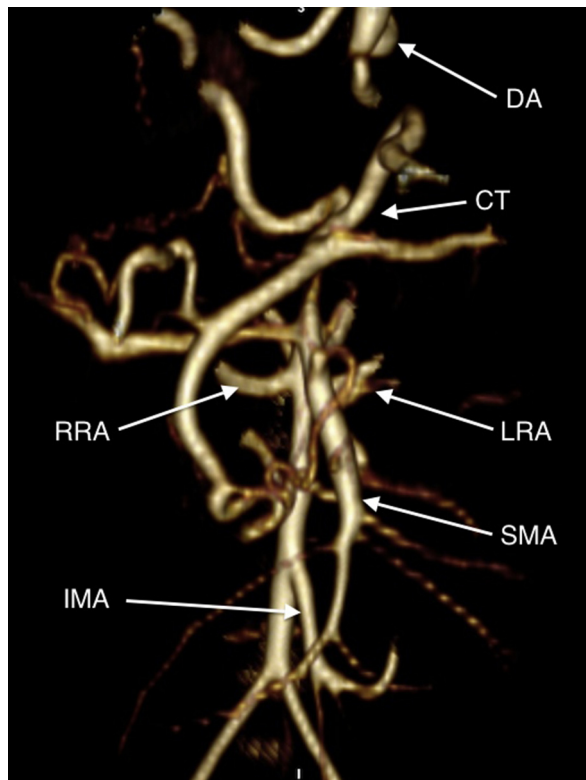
A preoperative a three-dimensional computed tomography angiography reconstruction demonstrates a segmental occlusion of the descending aorta to the midabdomen. A robust collateral circulation was seen for the infrarenal aorta and a retrograde flow into renal and mesenteric arteries. *CT*, Celiac trunk; *DA*, descending aorta; *IMA*, inferior mesenteric artery; *LRA*, left renal artery; *RRA*, right renal artery; *SMA*, superior mesenteric artery.
